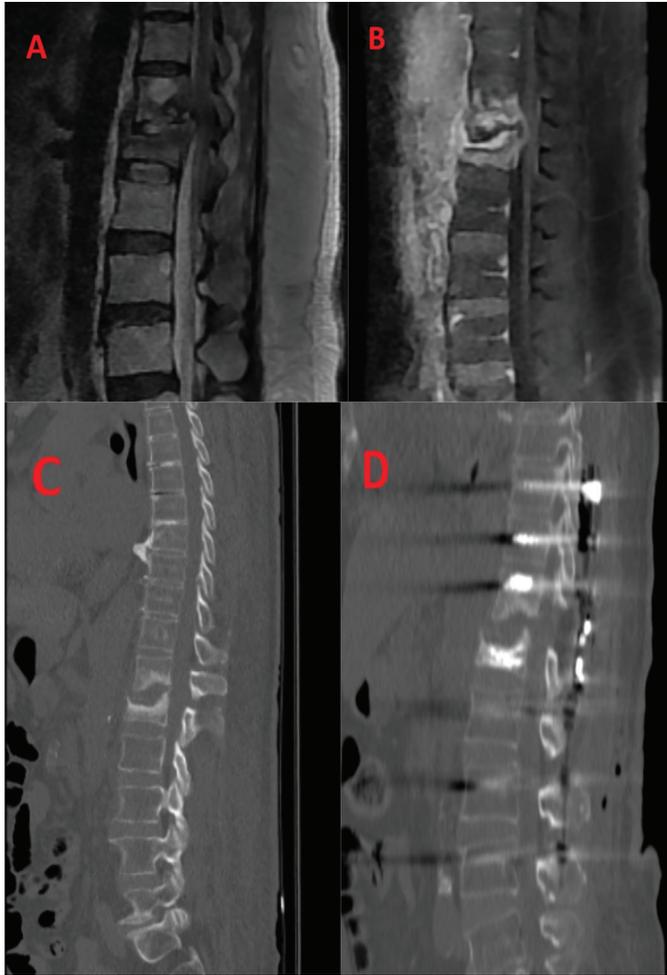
(A) Preoperative MRI demonstrating destructive spondylodiscitis at the T12-L1 level with epidural canal invasion in a patient presenting with neurological deficit. (B) Preoperative contrast-enhanced MRI of the same patient showing enhancement consistent with infectious involvement. (C) Preoperative CT image demonstrating bony destruction at the T12-L1 level. (D) Postoperative imaging of the same patient after surgical treatment showing debridement, posterior stabilization, and vertebroplasty performed for infection control and spinal stability. MRI: Magnetic resonance imaging, CT: Computed tomography
